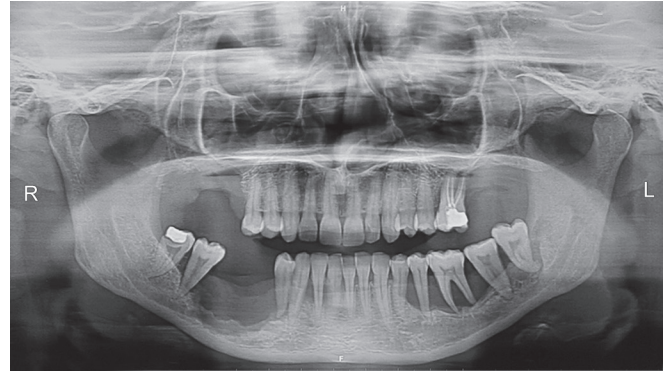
Orthopantomogram (OPG) showing aggressive alveolar destruction
